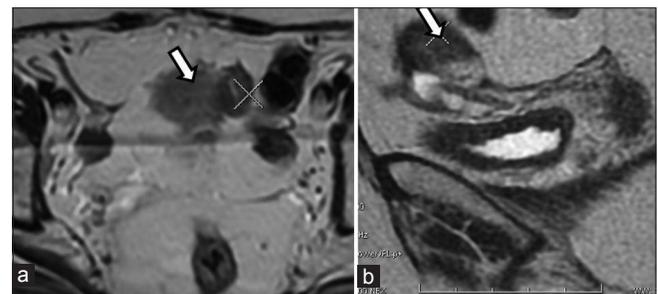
Magnetic resonance imaging demonstrating a heterogeneous hyperintense lesion (arrow) on axial T2 (a) and sagittal T2 weighted images (b). The lesion was close to the sigmoid colon (X) with distinct plane between the two. It was hypointense on precontrast T1 weighted and showed enhancement on postcontrast T1 weighted sequence
